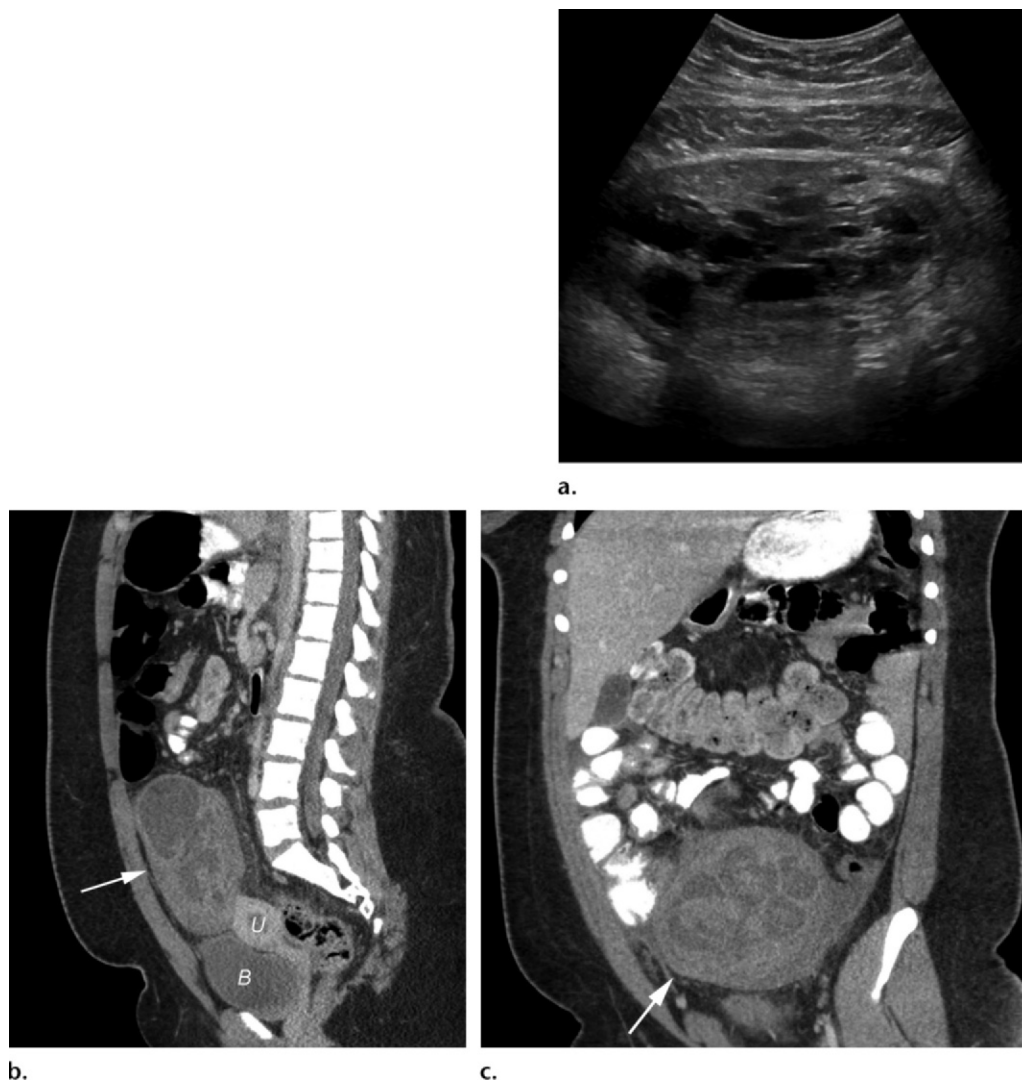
Ovarian torsion in a 14-year-old girl with abdominal pain of 3 days' duration. (a) Transverse US image of the pelvis shows an enlarged right ovary with multiple central cysts. (b, c) Sagittal (b) and coronal (c) CT images of the pelvis show a thick-walled mass (arrow) with central areas of low attenuation. At surgery, the mass was found to be a torsed right ovary. Pathologic analysis results confirmed the diagnosis of ovarian torsion with hemorrhagic necrosis. B = bladder, U = uterus.
